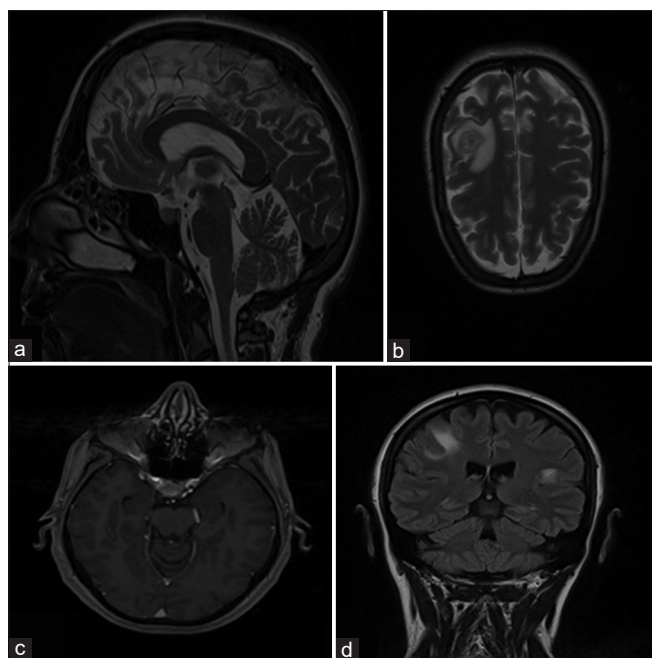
Cerebral magnetic resonance imaging: (a) sagittal view of T2-weighted image showing a pituitary mass, (c) axial view of T1 fat-saturated postgadolinium image showing enhancement of the pituitary mass, (b) axial view of T2-weighted image showing a right parietal subcortical mass surrounded by perilesional edema, (d) coronal flair image showing a bilateral parietal tissue lesion
